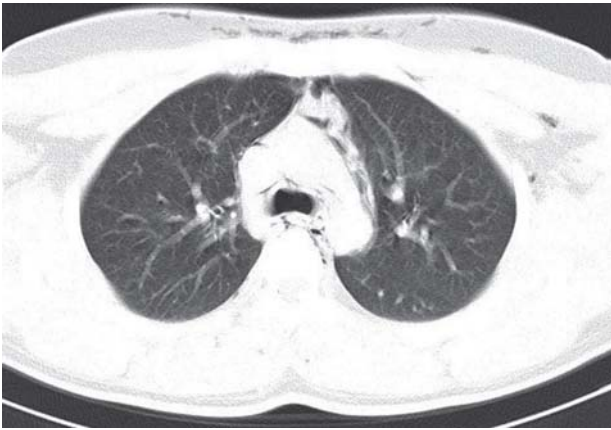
Computed tomography at the root of neck showing subcutaneous emphysema and spontaneous pneumomediastinum air around the great vessels.
